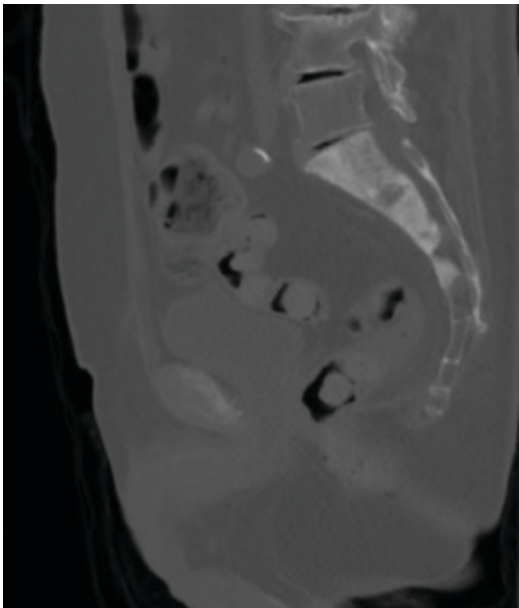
CT of patient with metastatic prostate cancer to sacrum
